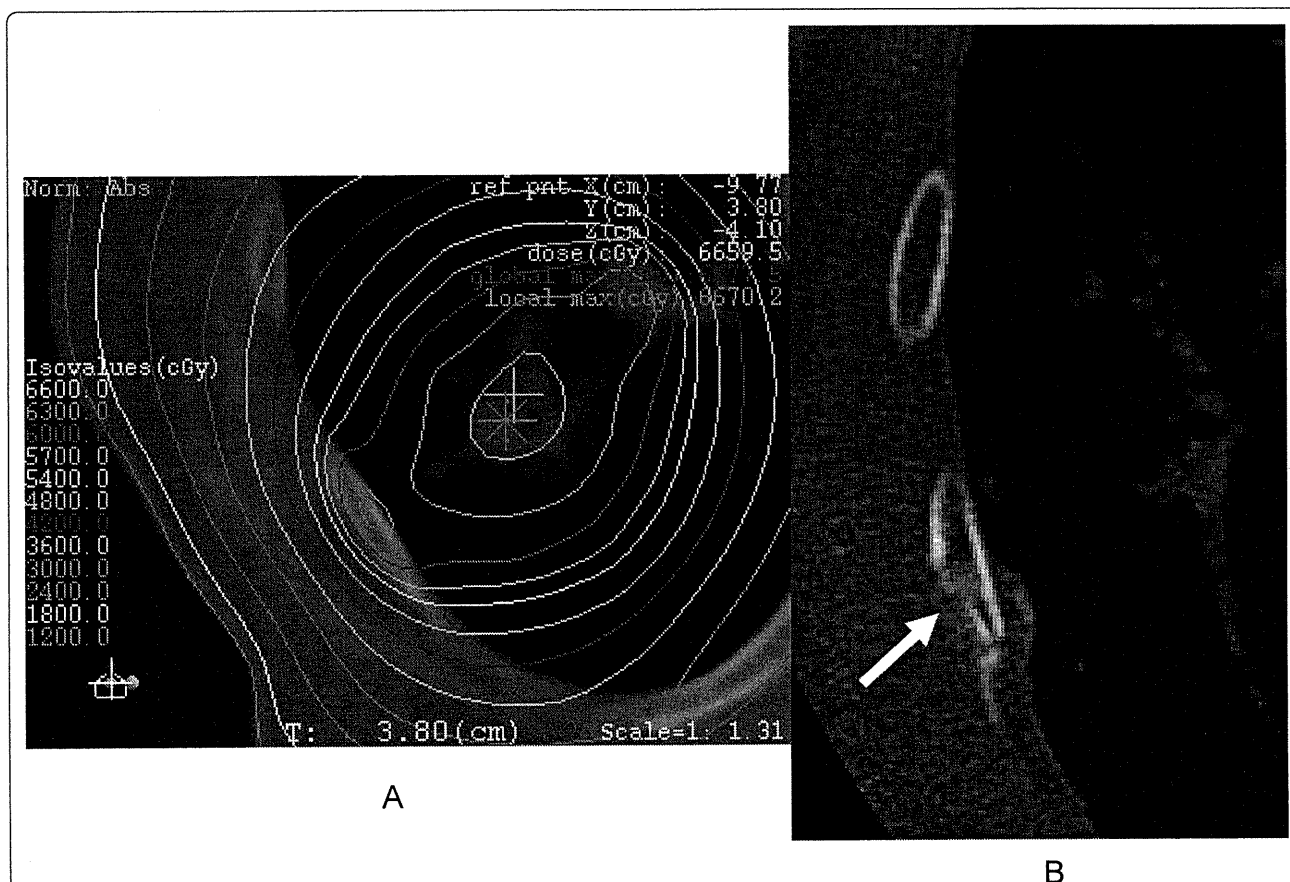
An 86-year old woman with adenocarcinoma. A: Dosimetry overlaying CT shows the maximum prescribed dose of chest wall as 63Gy, with a BED_3 of 233.2Gy. B: Rib fracture was noted at 24 months after completion of SRT. Amorphous osteosclerosis is also seen (arrow).
